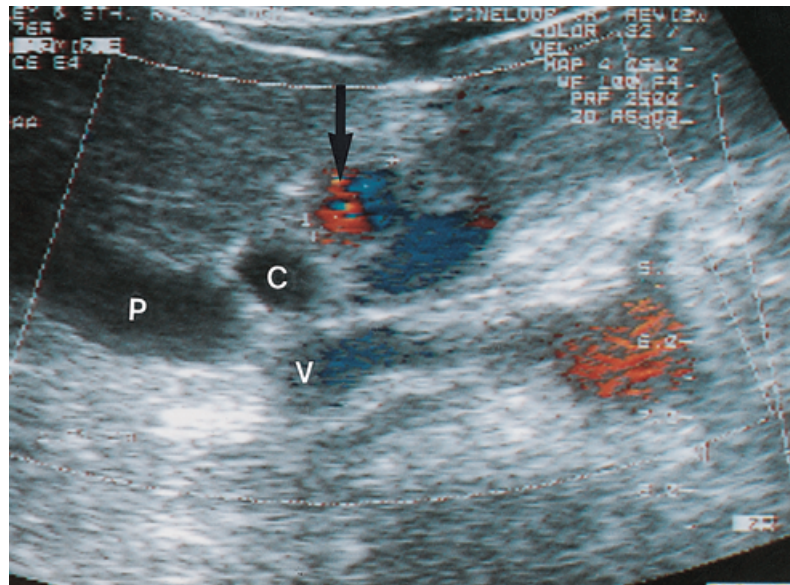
Transverse color Doppler sonogram demonstrates bidirectional blood flow within the cyst-like lesion (arrow). C, common bile duct; P, portal vein; V, inferior vena cava.
